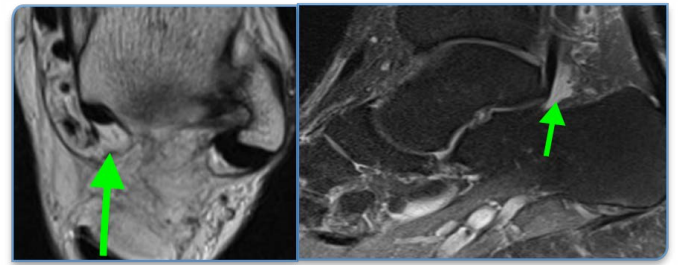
(left) Substantial fluid collection (green arrow) around the FHL tendon on sagittal MRI view (right) Substantial fluid collection around the FHL tendon (green arrow) on coronal MRI view.
